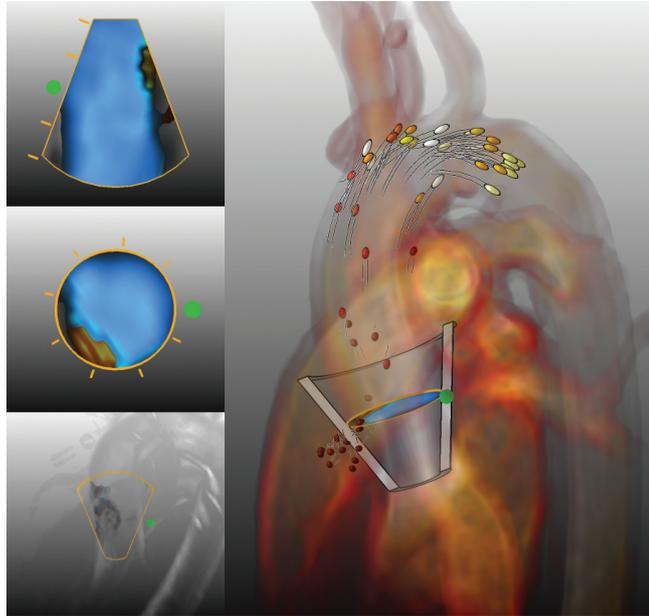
Video 1: All elements are included in the compound view. The probe serves as a basis for 3D geometry-based flow visualizations. The associated planes are updated when the probe is repositioned. They convey the blood-flow velocities inspired by Doppler US and 2D cine PC-MRI. Furthermore, the VFVR approach provides a holistic view of anomalous regions in the blood-flow field. <http://dx.doi.org/doi.number.goes.here>
